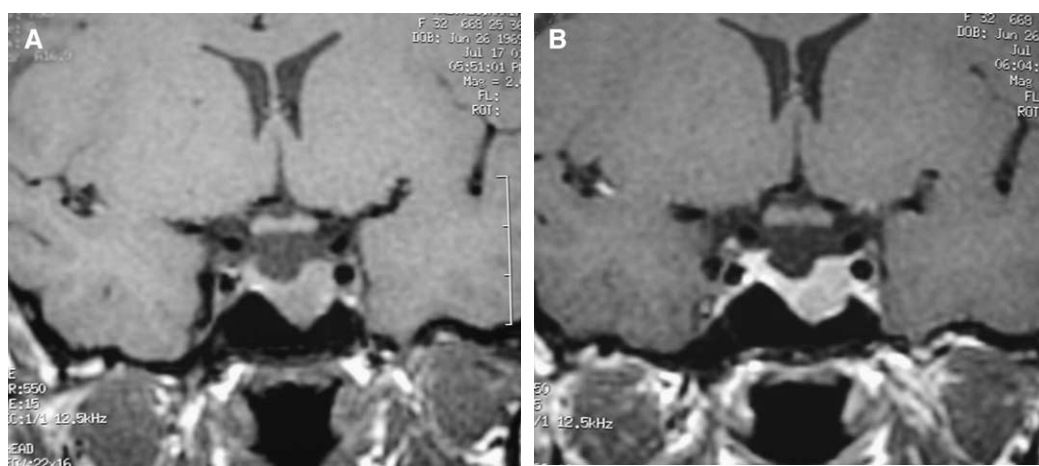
Pituitary microadenoma (prolactinoma). (A) Coronal T1-weighted image shows a focal mass on the left side of the pituitary gland with remodeling of the floor of the sellar turcica on the left side as well as superior convexity of the upper margin. (B) Coronal postcontrast T1-weighted image shows decreased enhancement of the mass compared with the pituitary.
